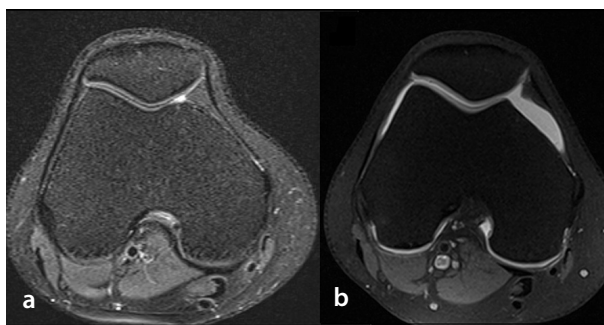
(b) Axial T1-weighted knee MR arthrogram obtained following intra-articular gadolinium injection shows the articular cartilage and capsule more clearly than pre-arthrographic axial PD MR imaging (a). MR, magnetic resonance; PD, proton density.
